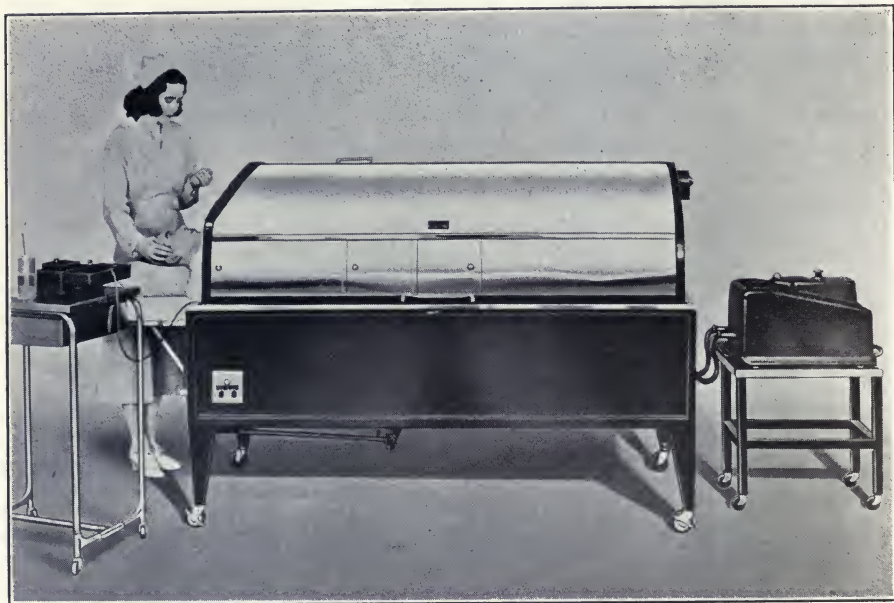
Inductance cable heating in fever cabinet. (Courtesy of the General Electric X-ray Corporation.)
